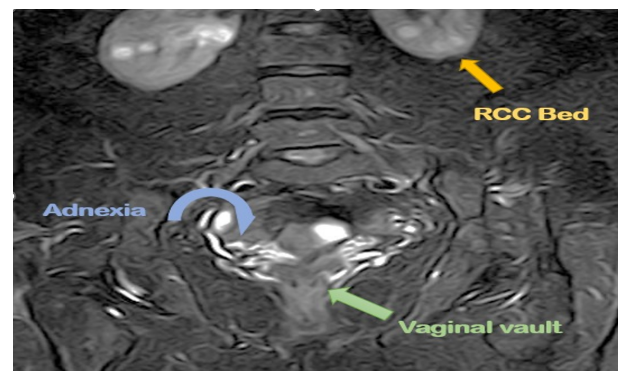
A magnetic resonance imaging coronal T2 fat sat sequence (after 1-year follow-up) shows a normal vaginal vault (green arrow), no adnexal lesion (blue arrow), and a clear bed of the lower pole of the left kidney (yellow arrow).
